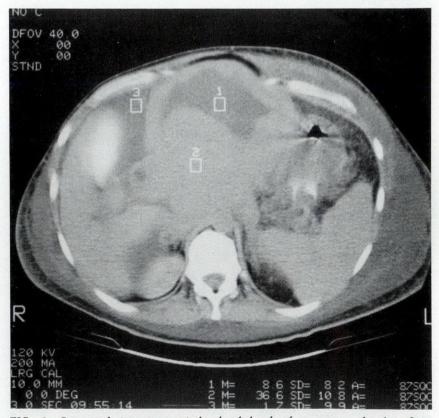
Computed tomogram at level of head of pancreas, showing 9-cm phlegmonous mass in head (2), fluid collection in anterior lesser sac (1) and free intraperitoneal fluid (3).
